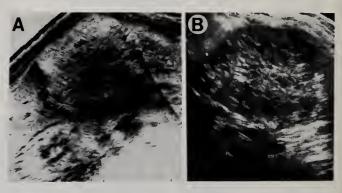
Transverse (A) and longitudinal (B) ultrasound images of the complex mass in the head of the pancreas. The lesion shows many bright internal echoes corresponding to the walls or septa of the multiple tiny cysts which make up the mass.
